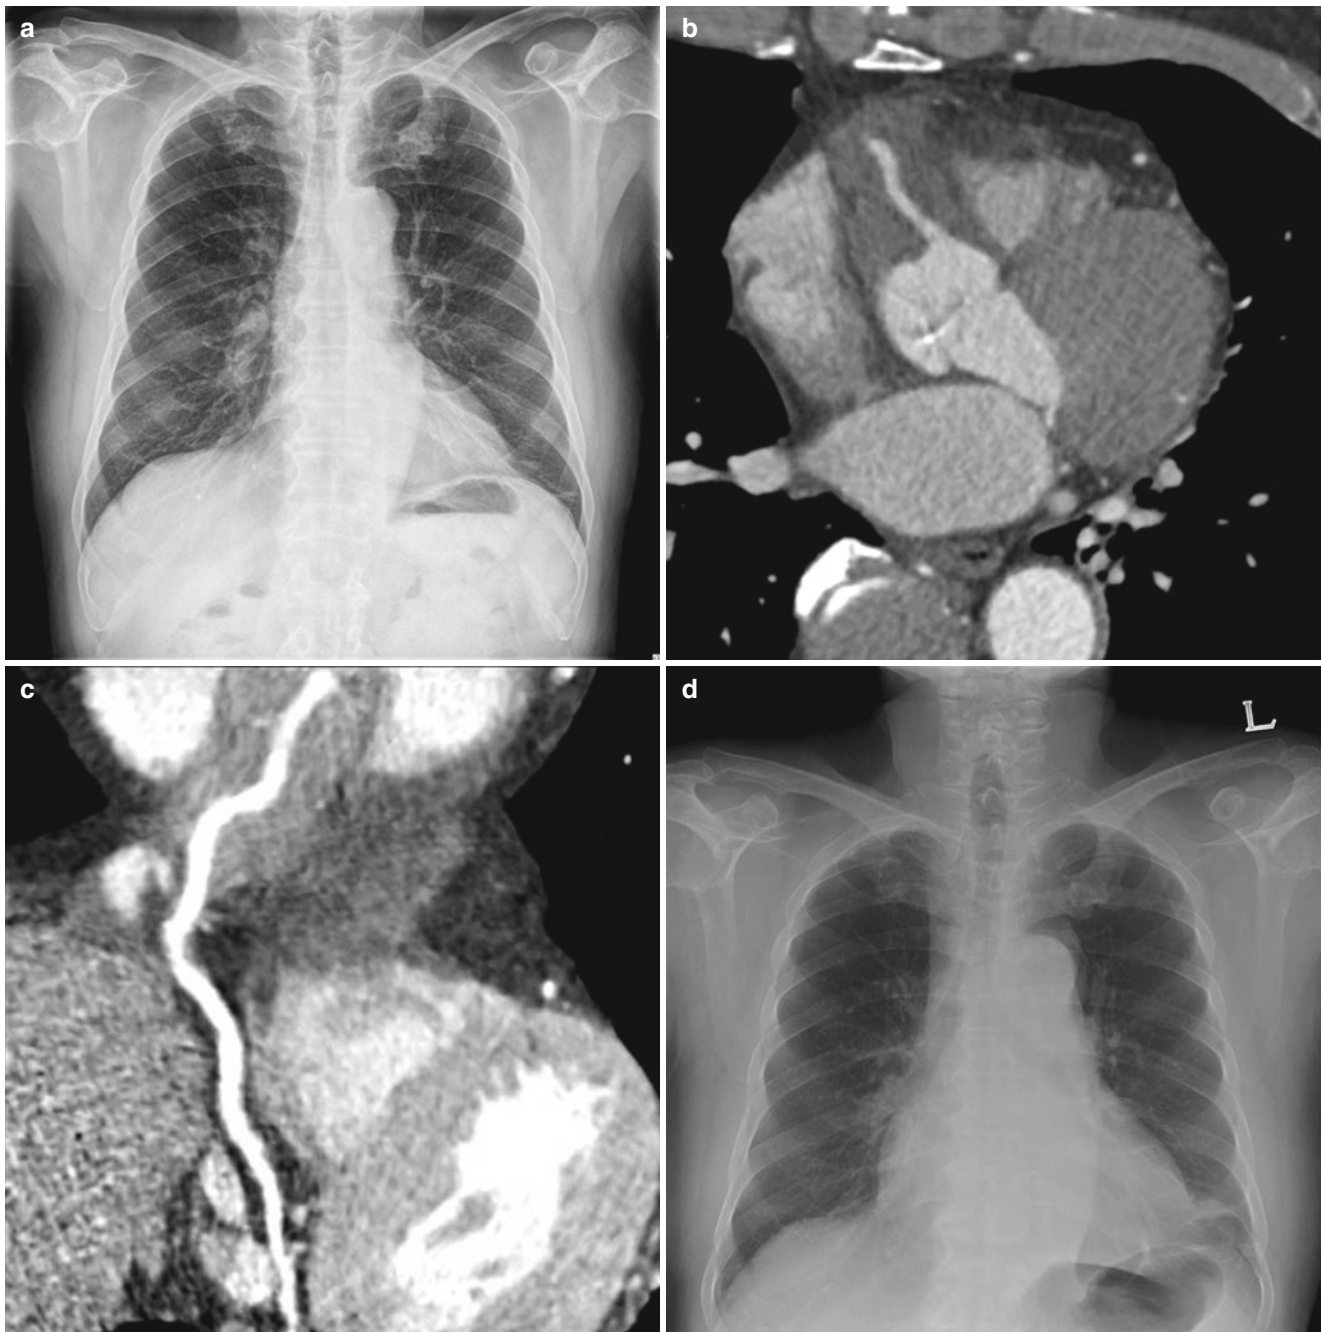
CT and CMR findings of cardiac lymphoma in a time period. (a) Chest radiograph acquired 1 month ago shows hypertensive heart configuration, but no cardiomegaly or increased pulmonary vascularity were seen. (b, c) CT coronary angiographies acquired 1 month ago show homogeneously enhancing soft tissue lesion surrounding the right coronary artery. But the right coronary artery was widely patent and there was no infiltration by the mass on the axial multiplanar
